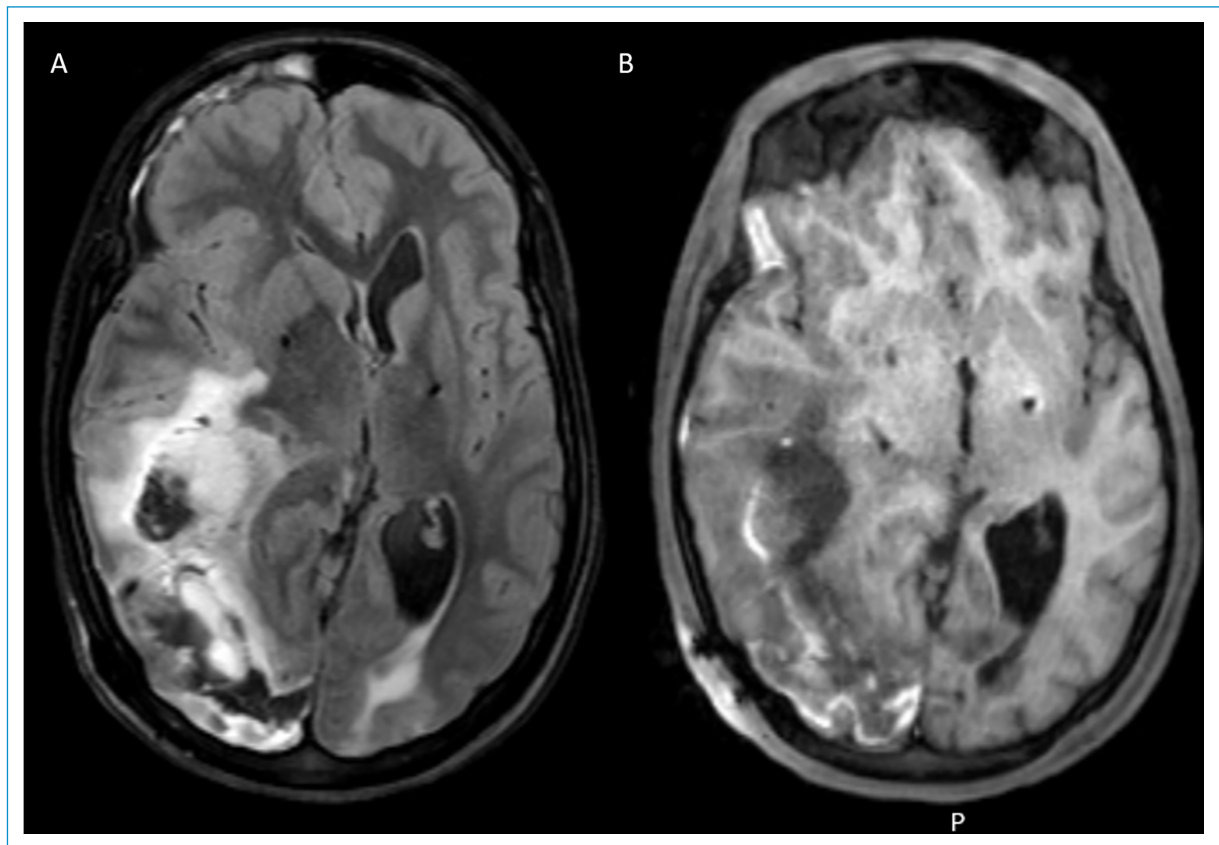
Brain magnetic resonance imaging showing (A) bilateral occipital T2 FLAIR subcortical hyperintensities, particularly on the right, (B) with T1 peripheral gadolinium enhancement and hemorrhage, causing subfalcine herniation, compatible with posterior reversible encephalopathy syndrome.
